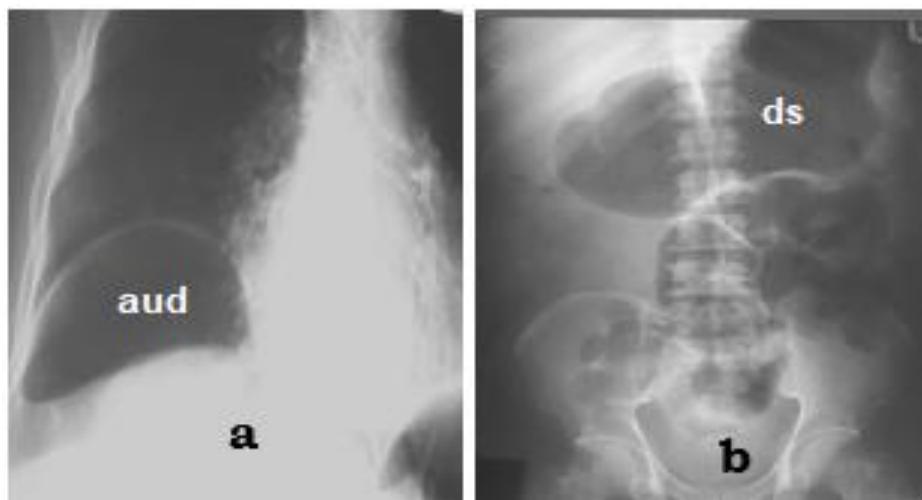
a. Chest radiograph showing air under the right hemidiaphragm (aud) due to intestinal perforation. b. Plain abdominal radiograph showing grossly dilated gas-filled stomach (ds) in acute gastric dilatation due to paralytic ileus caused by head injury.
